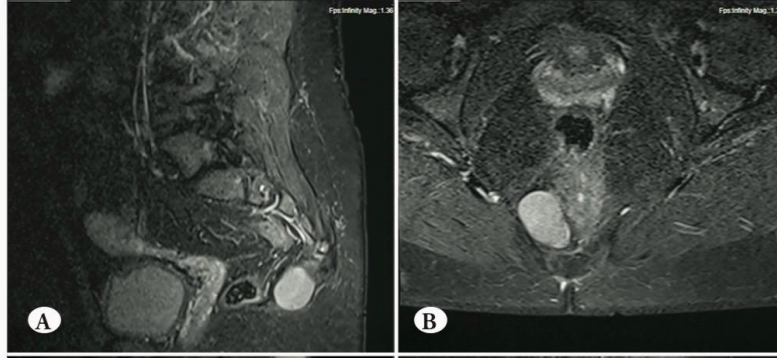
Axial and sagittal MRI images demonstrating the tailgut cyst.
